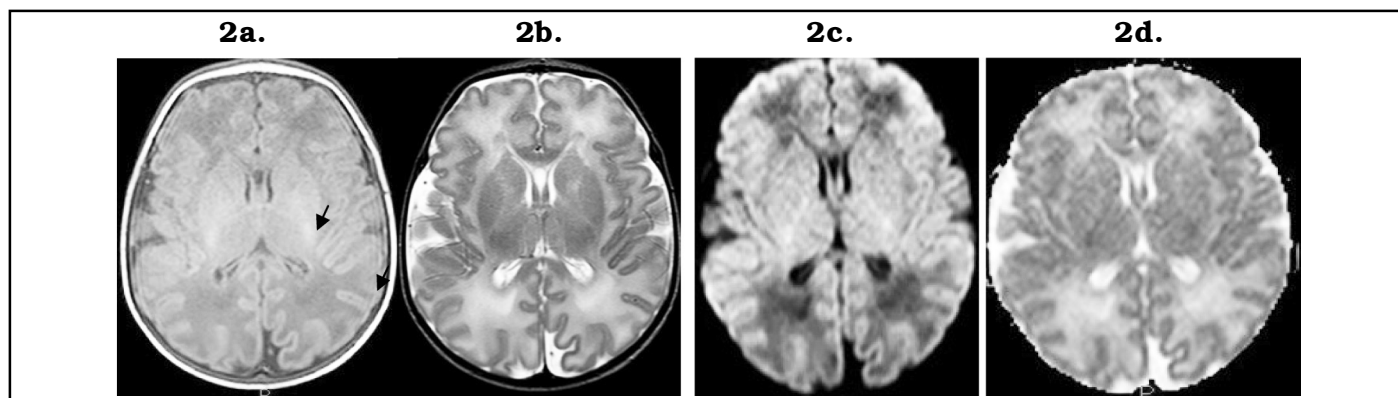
(2a to 2d) Term infant MRI brain
